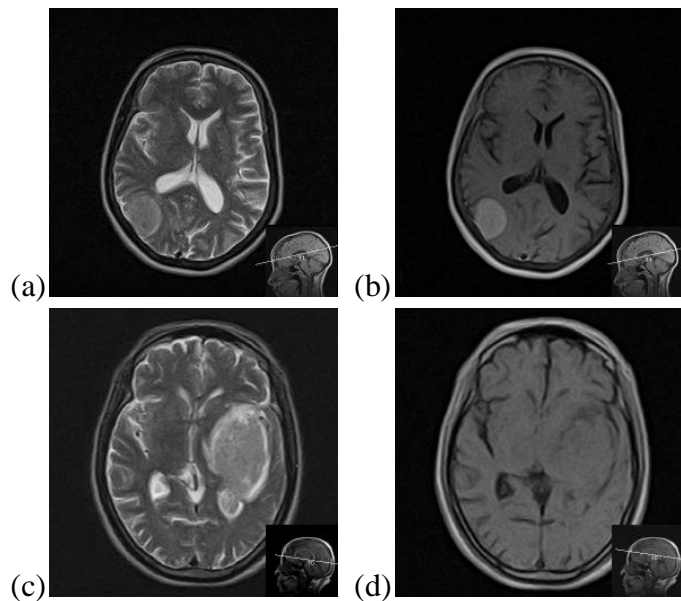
Tumor region intensity characteristics, Original raw MRI data from Pioneer Diagnostic center. (a) and (c) T2-w images, (b) and (d) T1-w images. Tumor region in a) low intensity, b) high intensity, c) high intensity and d) low intensity
